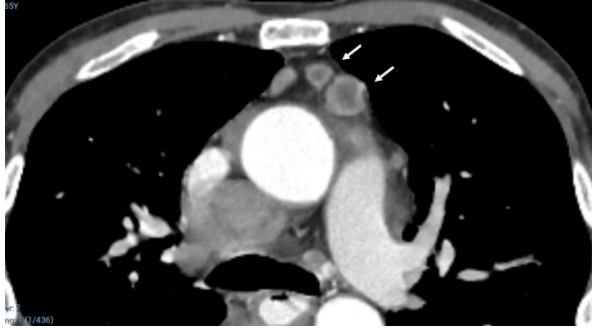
CT image of a patient with tuberculosis showing mediastinal lymph nodes (arrows) characterized by central necrosis and peripheral contrast enhancement, typical of tuberculous lymphadenopathy.
